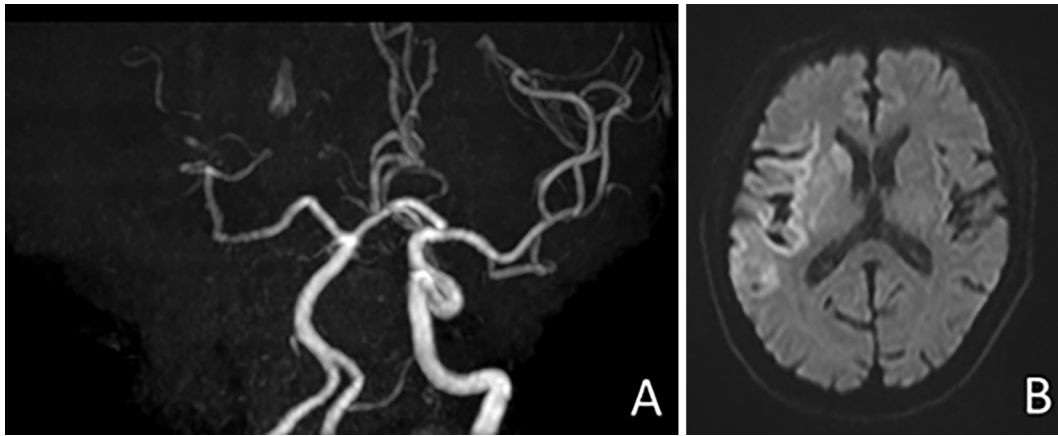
(A) MRA showing occlusion of the right internal carotid artery. (B) Diffusion-weighted MRI showing a high signal intensity at the right basal ganglia and temporal lobe.
